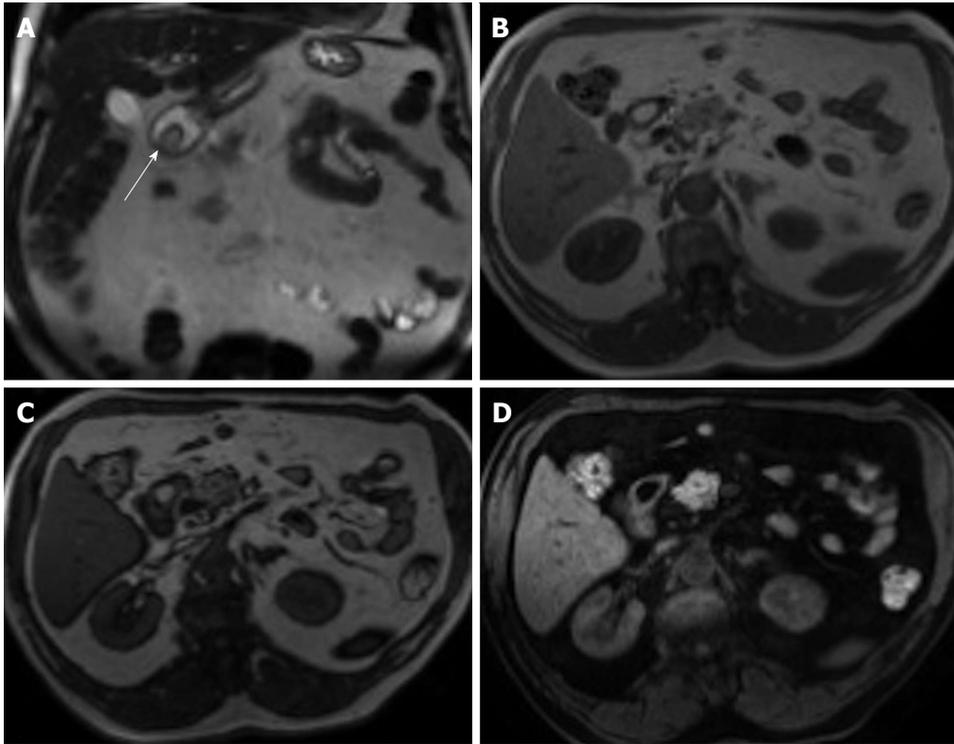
Duodenal lipoma. A: Coronal T2-weighted single shot fast spin echo (SSFSE); B: Axial GRE in-phase; C: Opposed-phase T1-weighted; D: Axial fat-suppressed 3D-GRE T1-weighted images. Small, well-defined, intra-luminal, duodenal mass lesion; which demonstrates intermediately high signal on SSFSE (arrow, A), high signal intensity on the in-phase T1 weighted image (B), no drop of signal on the opposed-phase images (C), and homogenously low signal intensity on the fat-suppressed image (D) in keeping with duodenal lipoma. GRE: Gradient recalled echo.
